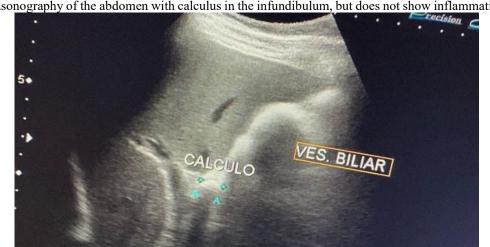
Ultrasonography of the abdomen with calculus in the infundibulum, but does not show inflammation with fistula.
